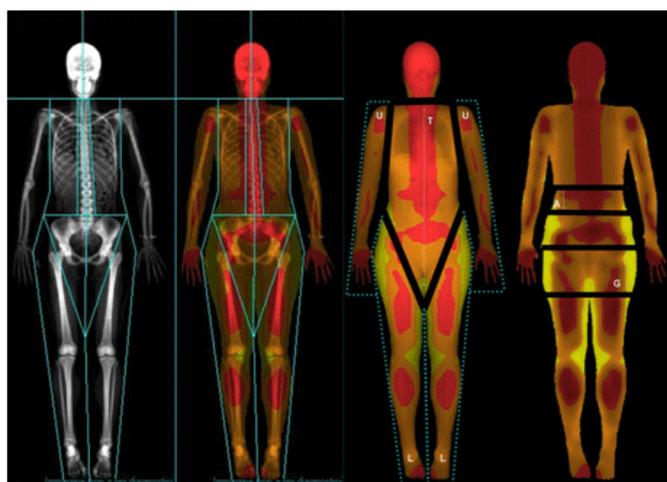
[Dual-energy x-ray absorptiometry whole-body analysis. The body is conventionally represented by coloured areas according to the percentage of fat mass. In the colour scale, ranging from red (low fat mass percentage) to yellow (high fat mass percentage), red is set for regions with composition under 25% of fat mass, orange for regions between 25% and 60% of fat, and yellow for fat over 60%. According to the regional assessment of body composition the figure shows U as upper limbs, T as trunk, L as lower limbs. A and G stand respectively for android and gynoid.
